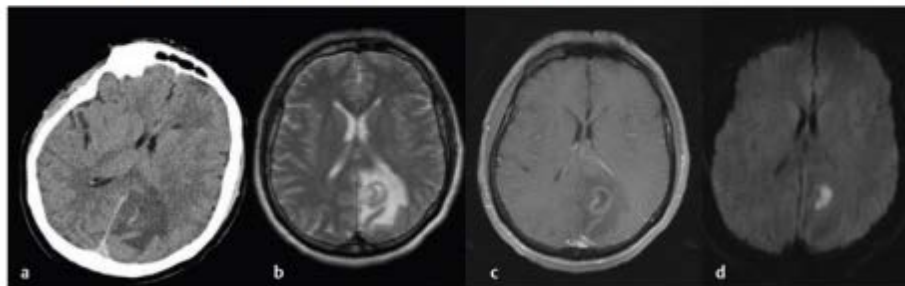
Imaging studies at the time of admission. (a) Computed tomographic scan without contrast showing left parietal edema with a central rim. (b) T2-weighted magnetic resonance imaging (MRI) demonstrating the hyperintense lesion in the left parietal lobe with surrounding vasogenic edema. (c) Contrast-enhanced T1-weighted MRI demonstrating a left parietal ring-enhancing lesion. (d) Diffusion-weighted imaging revealing restricted diffusion.
